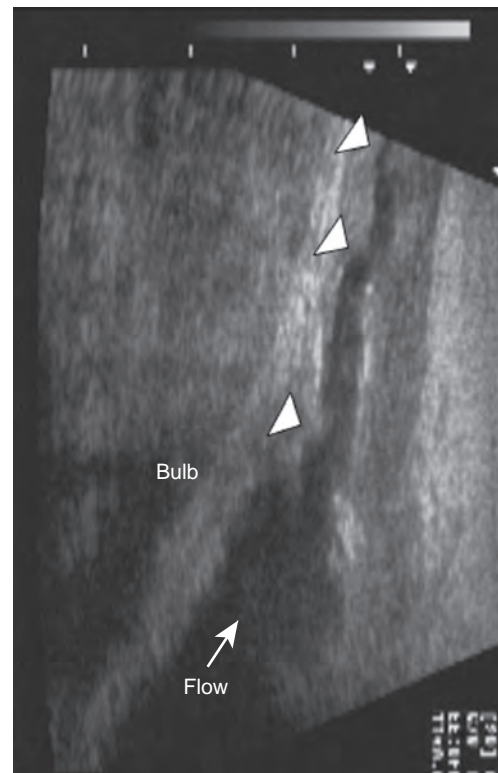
Urethral ultrasonography has been used to assist in assessing the urethra in a noninvasive fashion. The arrowheads indicate the direction of urine flow during voiding in a normal urethra without stricture. (Courtesy Jonathan Rhee, MD.)
